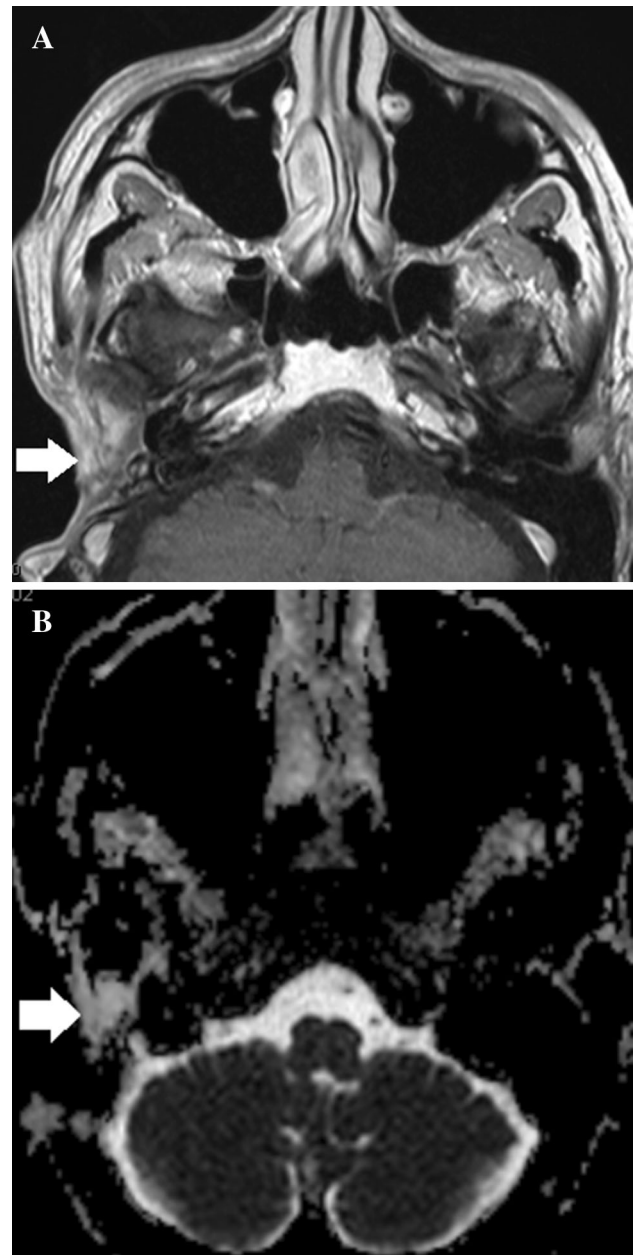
(a) Postgadolinium T1-weighted image from a 65-year-old male with previous surgery for squamous cell carcinoma of the pinna shows an enhancing lesion posterior to the right temporomandibular joint (arrow). (b) The corresponding ADC map shows high signal (arrow) indicating increased ADC values, and suggestive of a benign process. This was biopsied and revealed to be benign granulation tissue
